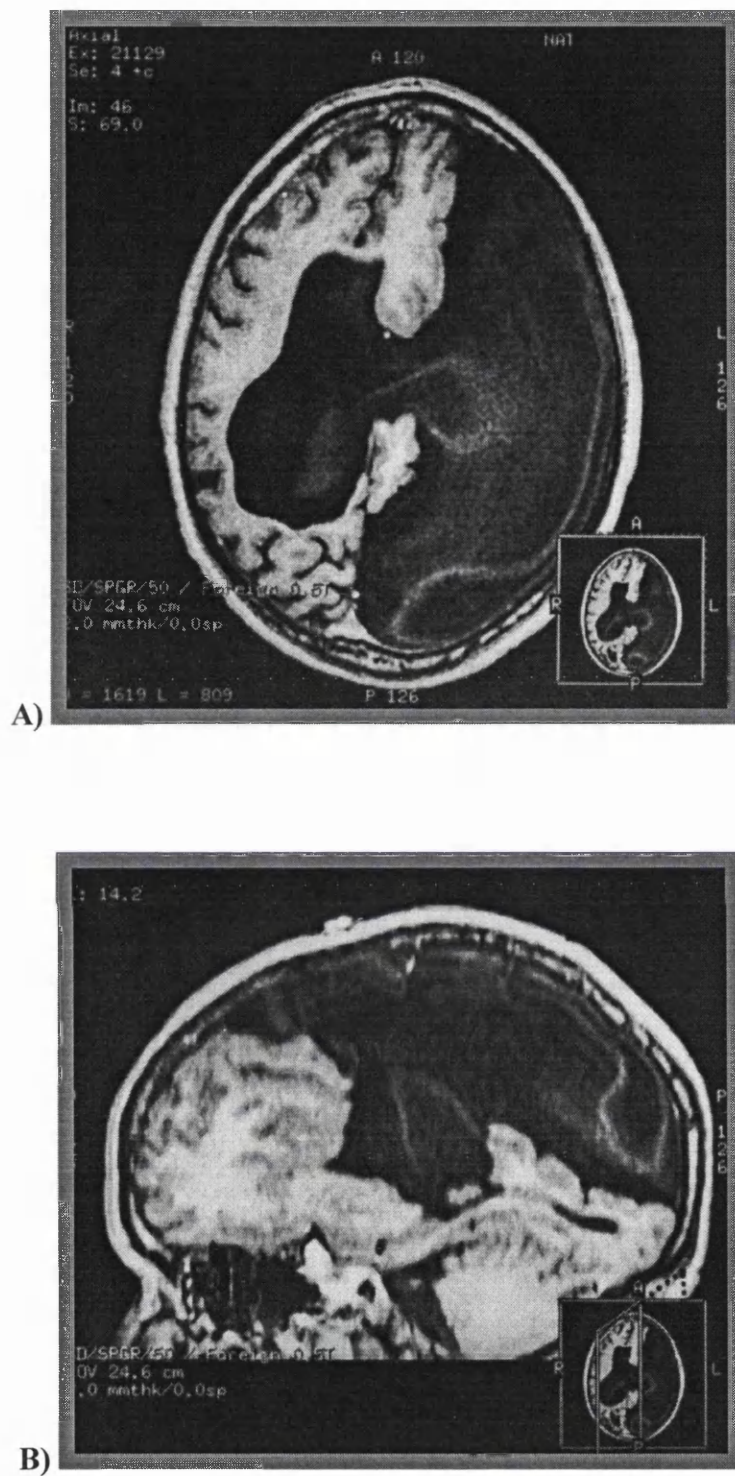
Pre-operative MRI for IGN case 3. The loculated collections, left-right shift of the midline and disorganised cerebral anatomy can be appreciated in these A) Axial and B) Sagittal views.
